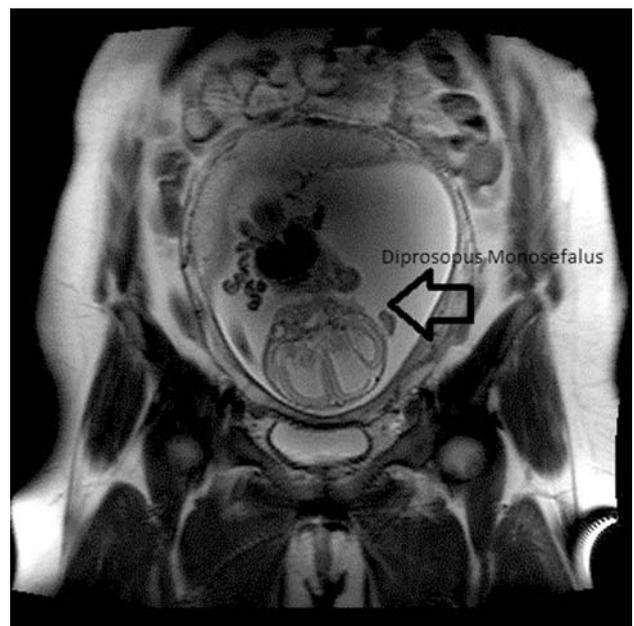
MRI view of double-face, single head.
